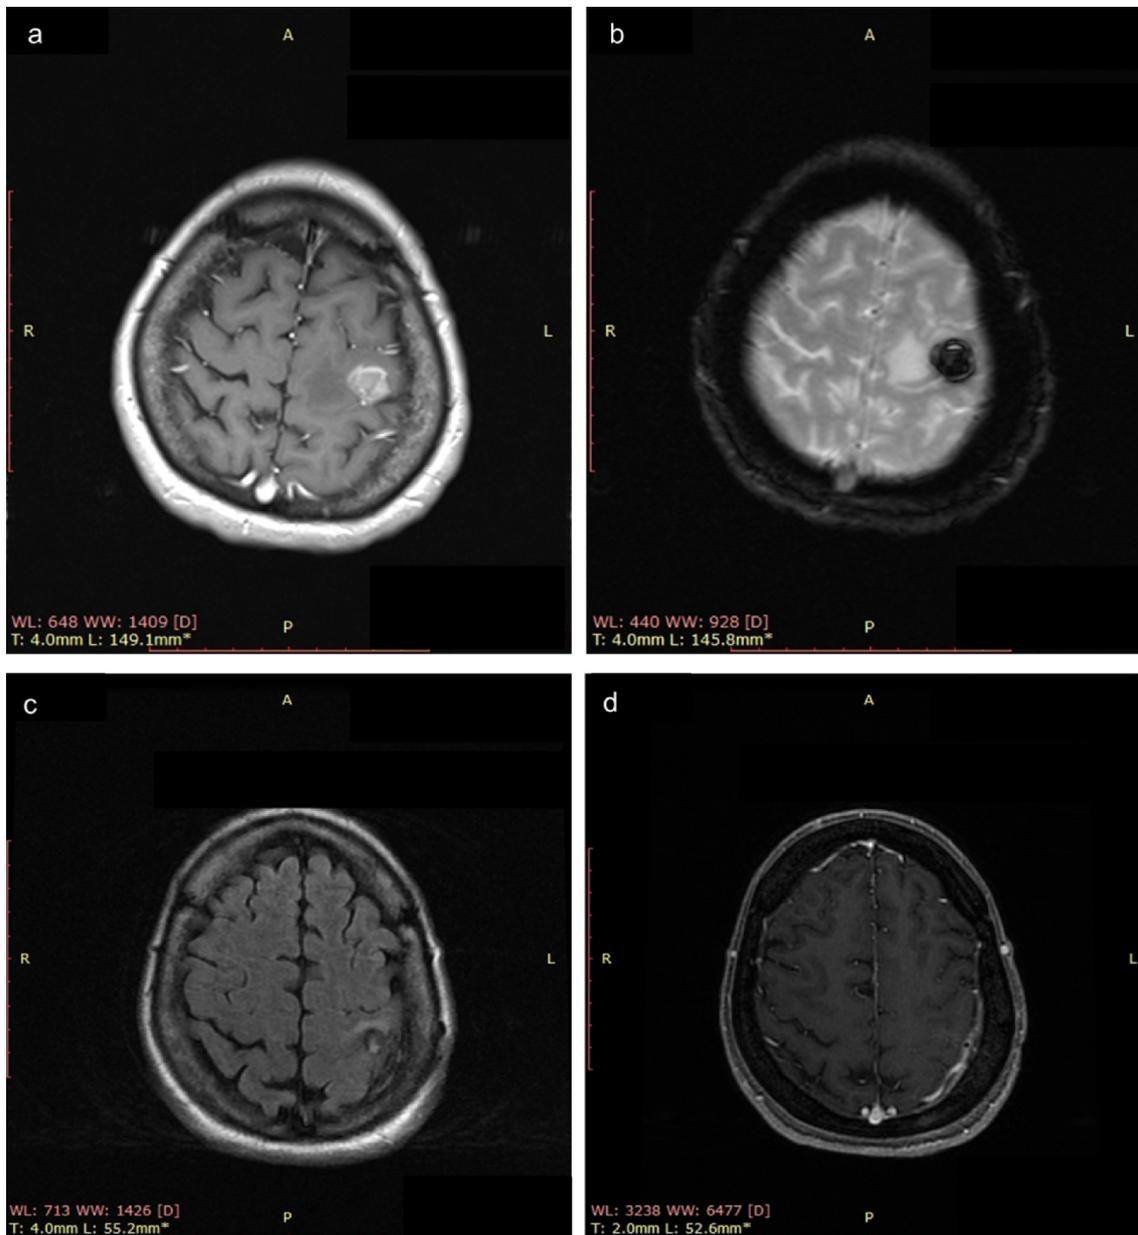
Pre-operative (a, b) and post-operative (b, c) MRI. a) axial, T1-weighted contrast-enhanced magnetic resonance imaging demonstrating a left pre-central lesion suggestive for metastasis, showing a not homogeneous contrast-enhancement surrounded by perilesional edema; b) axial, T2-weighted gradient-echo magnetic resonance imaging demonstrating the same left pre-central lesion with hemosiderin content, due to recent bleeding, surrounded by perilesional edema. c) axial, T2-weighted FLAIR magnetic resonance imaging demonstrating the metastasis total resection, associated with significant reduction of perilesional edema; d) axial, T1-weighted contrast-enhanced magnetic resonance imaging acquired post-operative, demonstrating the metastasis total resection.
